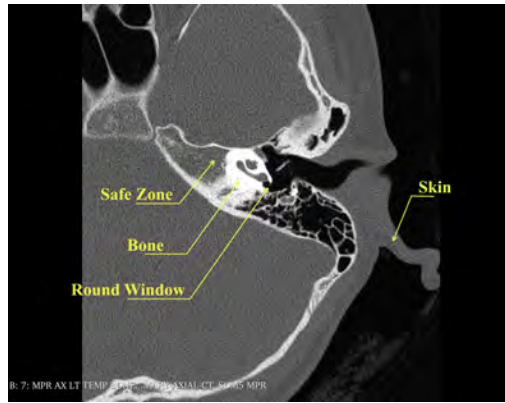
CT images of the anatomy of the skin, bones, safe zone (including important blood vessels and nerves), and round window in patient code 20221116.
